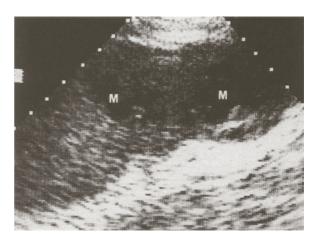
Splenic abscess. Hypoechoic images (*M*) within an enlarged spleen. The ultrasound-guided tap revealed pus with *Staphylococcus* in this 48-year-old male with endocarditis
